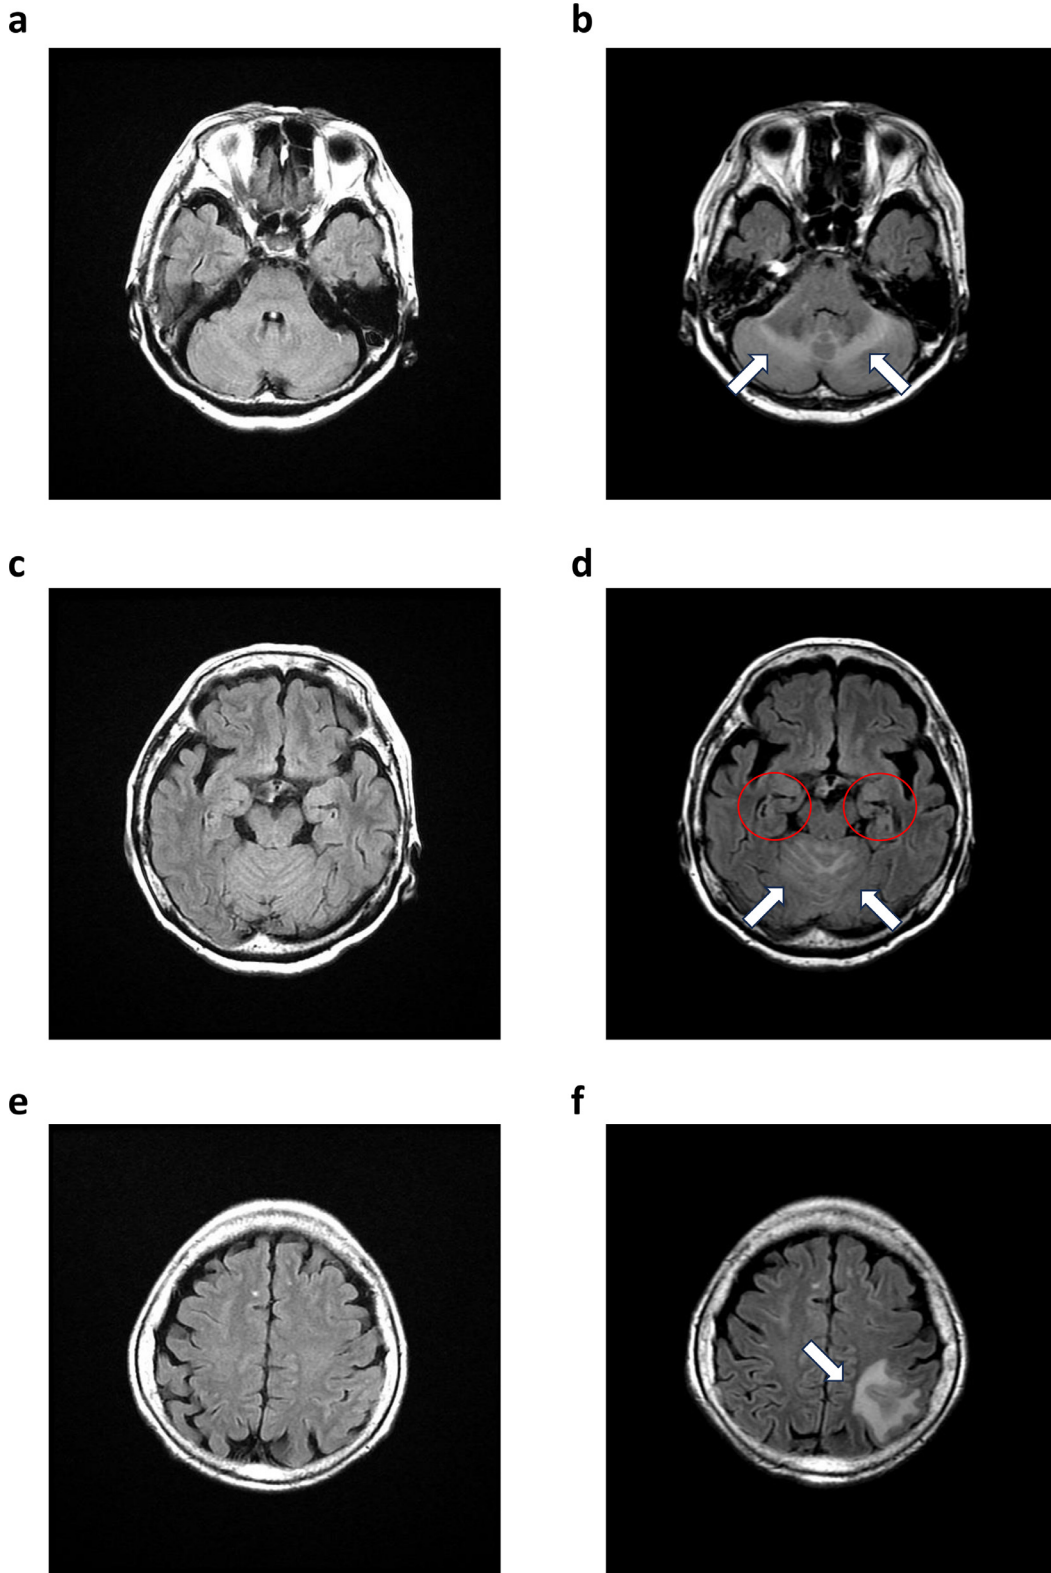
FLAIR (a, c, e) MRI performed on the day of admission does not reveal any abnormalities. At the onset of PIRS on the 52nd day of treatment (b, d, f) hyperintense lesions are observed in the cerebellum (arrows) (b) and middle cerebellar peduncles (arrows) (d) on FLAIR. The inferior horn of the lateral ventricle (red circles) is enlarged compared with previous images, suggestive of hydrocephalus (d). Cerebral edema is observed in the cortex and subcortical white matter of the left parietal lobe (arrows) (f), combined with high FLAIR intensities.
